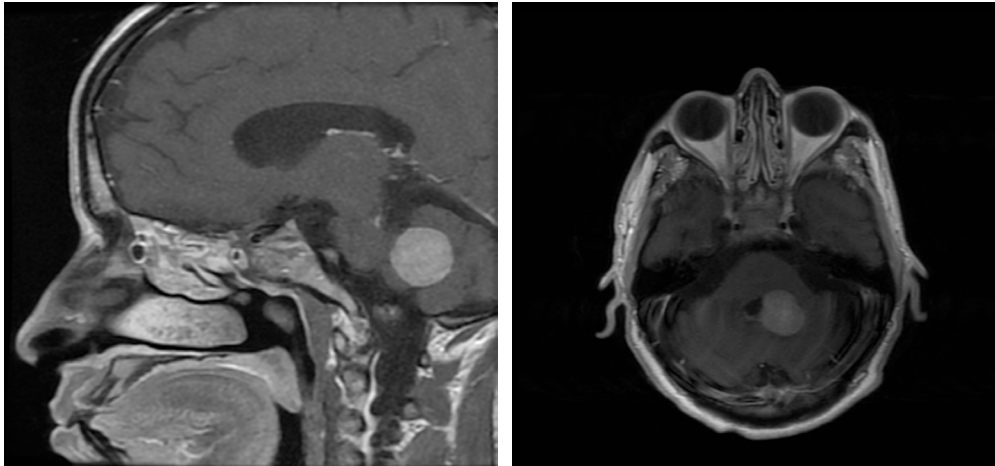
(A) Sagittal and (B) Axial post contrast T1-weighted MRI images show an enhanced intraventricular mass lesion.
